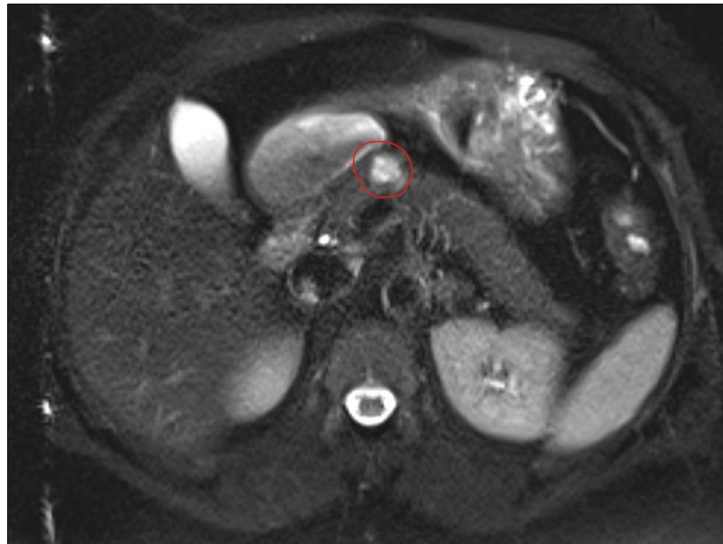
MRI, axial view of the tumour
